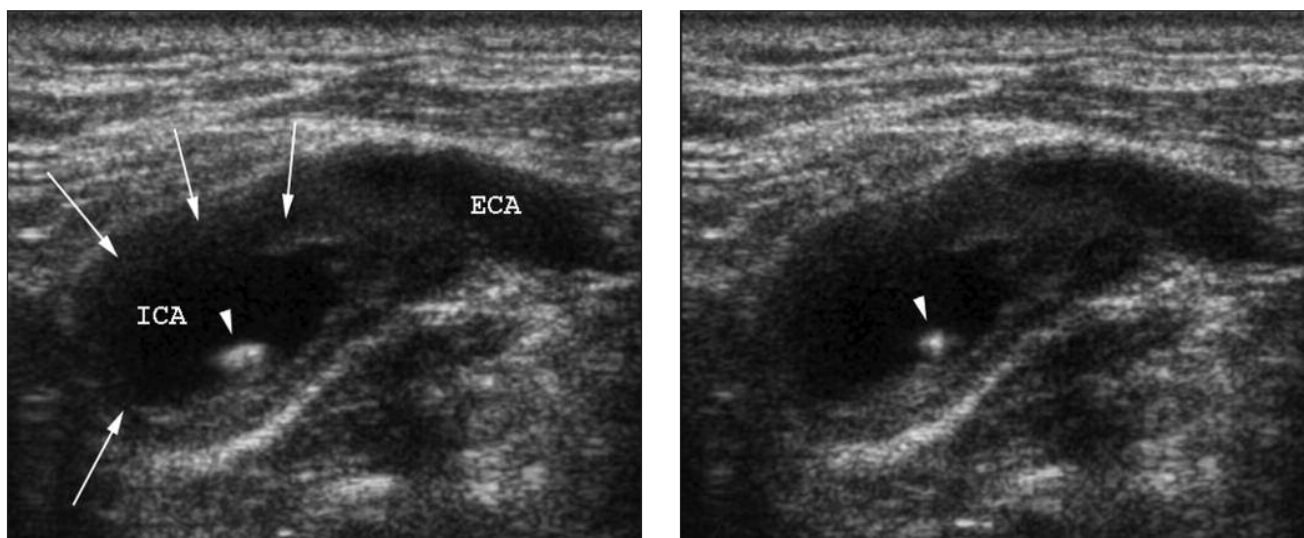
Cross-sectional ultrasound images of the left internal carotid artery. The images captured in different phases show the circular heteroechoic plaque (arrows) and the mobility of the echogenic thrombus attached to the surface of the plaque (arrowhead). (Abbreviations: ICA=internal carotid artery; ECA=external carotid artery)
